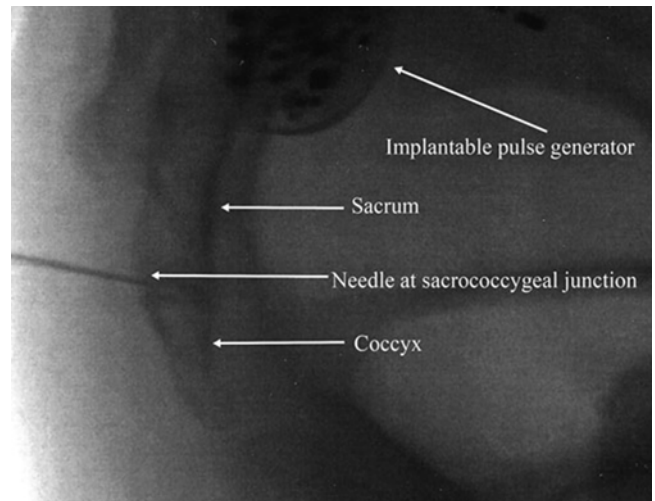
Lateral radiographic view of transsacrococcygeal approach
